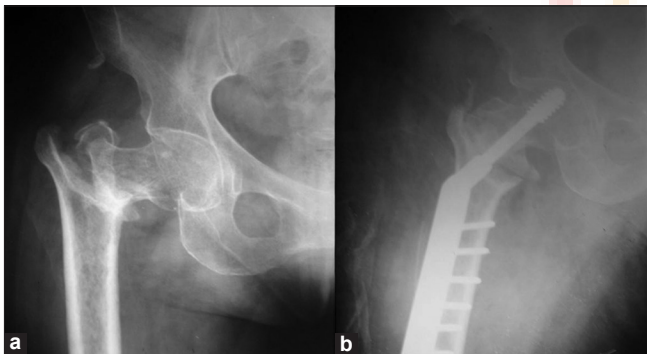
X-ray right hip anteroposterior view 6 1/2 months after injury showing (a) nonunion (b) 6 weeks after surgery
